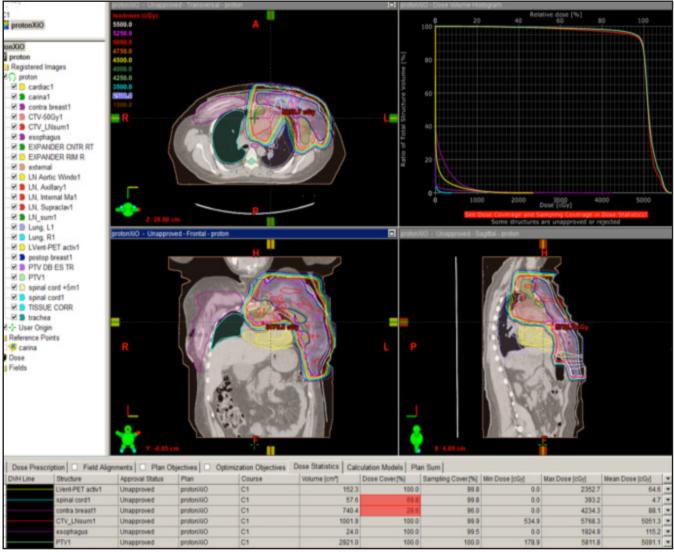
The case of a postmastectomy breast cancer patient with biopsy-proven and/or PET/CT-positive lymphadenopathy in the left axilla, internal mammary region, subaortic arch, and supraclavicular region. The plan was able to spare the left ventricle, esophagus, and brachial plexus, while delivering 50 Gy to all involved nodal regions and the entire chest wall. Two 30-cm fields were employed.³³
